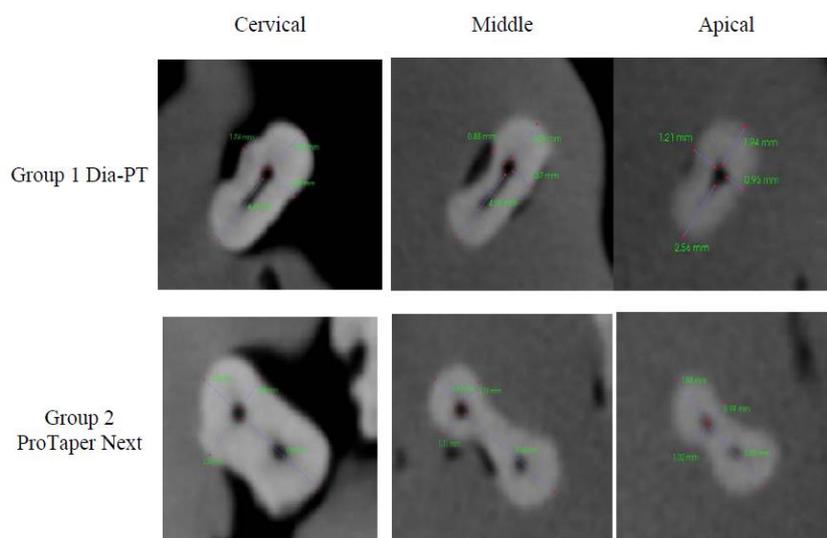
CBCT axial view showing effect of file type on canal transportation and centering in 3 zones.
